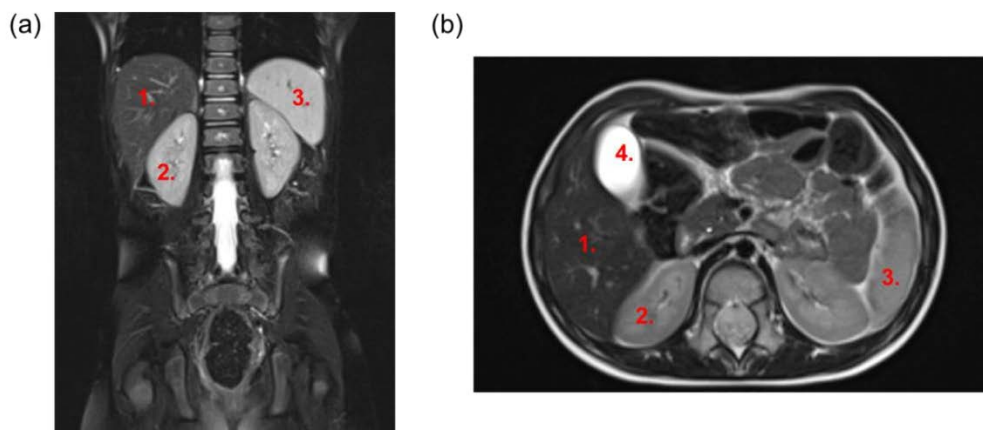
Abdominal MR imaging. Abdominal MR T₂-weighted images in (a) coronal and (b) axial planes. Locations of the large abdominal organs are indicated with numbers: 1. liver, 2. kidney, 3. spleen, and 4. gall bladder.
